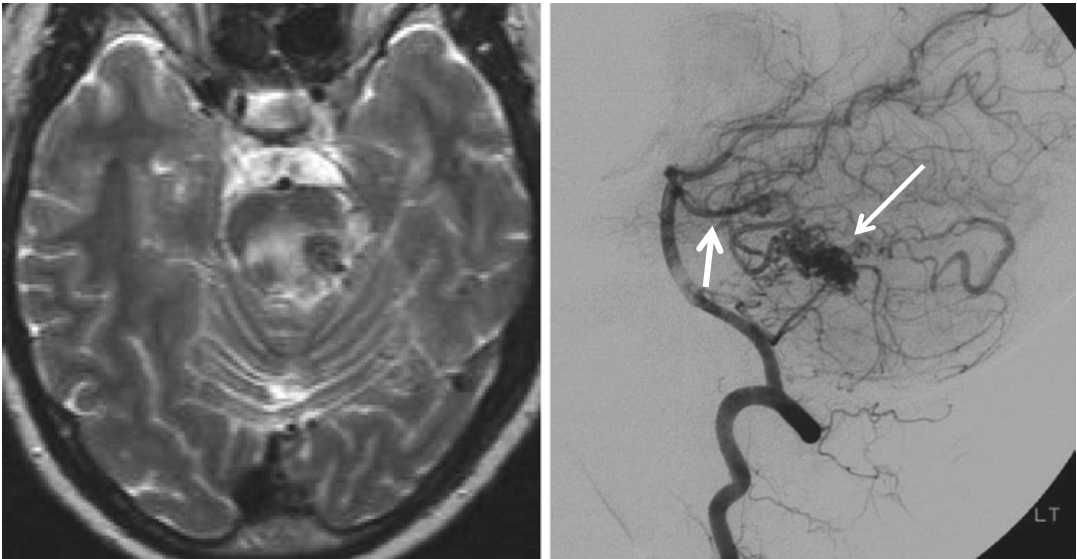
A 42-year-old woman developed dizziness and tingling sensation in the right extremities. Left image: T2-weighted Brain MRI showed a round, dark signal intensity with adjacent high signal intensity signals consistent with acute hemorrhage surrounded by edema.
